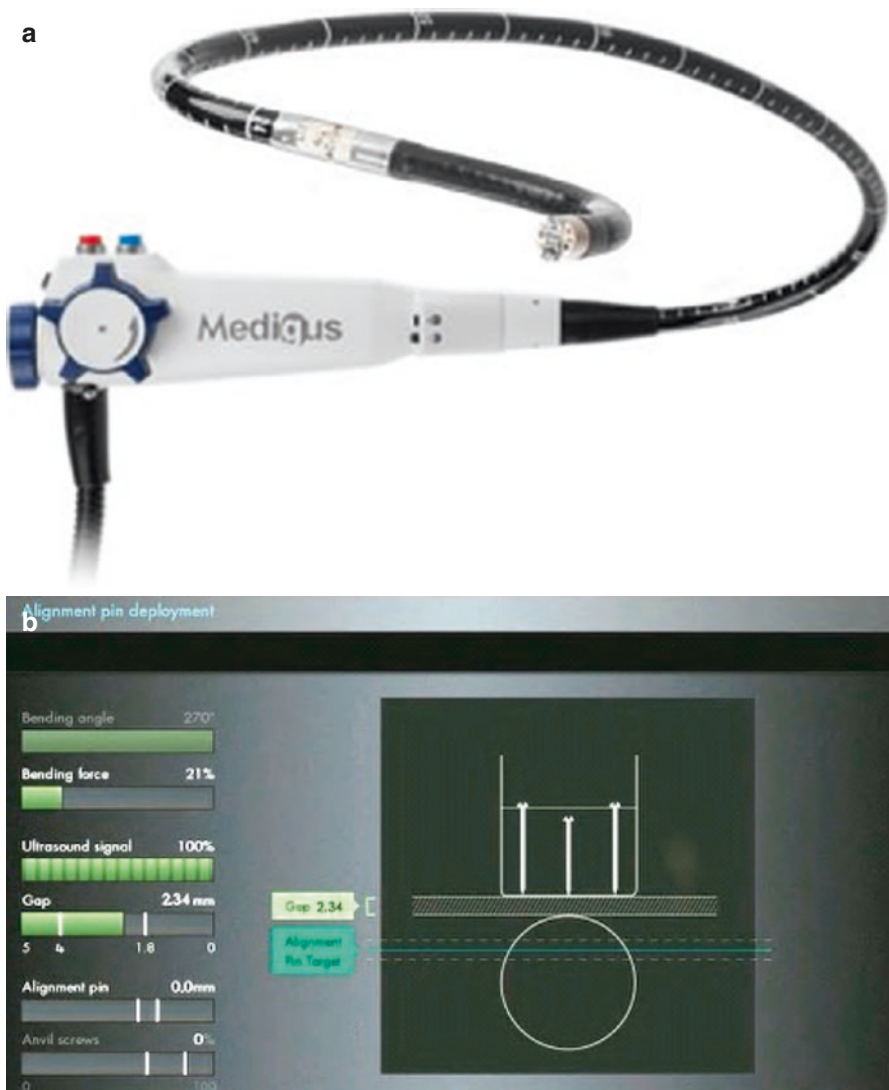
The Medigus Surgical Ultrasonic Endostapler system, MUSE™ (Courtesy of Medigus Ltd., Omer, Israel). (a) The MUSE™ system (© All rights reserved to Medigus Ltd. 2008–2015); (b) the console connected with the endostapler, containing a controller for the camera, ultrasonic range finder, and various sensors (bending angle, bending force, alignment pin, anvil screws, gap) (© All rights reserved to Medigus Ltd. 2008–2015)
